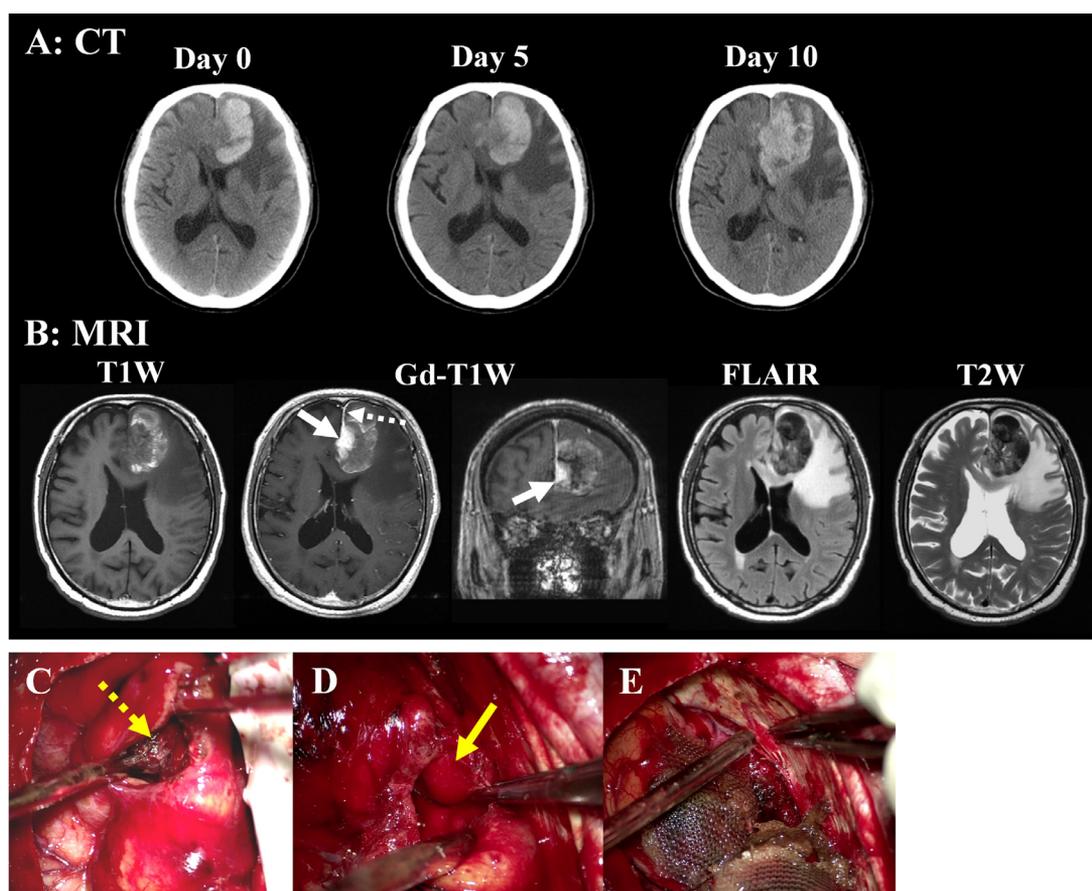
(A) Computed tomography images on admission (Day 0) demonstrating a high-density mass suggesting hemorrhage in the left frontal lobe with large low-density area. On Day 5, the high-density area has spread to the right frontal lobe. The hematoma has enlarged further by Day 10, severely compressing the lateral ventricle. All CT images were performed without contrast media. (B) Magnetic resonance imaging on Day 5 displaying high-signal lesions on T1W, suggesting acute hemorrhage. Gd-T1W demonstrates definite enhancement in or adjacent to the falx (white arrows) with a dural tail sign (dotted arrow), suggesting that the enhanced mass is attached to the falx. FLAIR and T2W demonstrate a massive intraparenchymal low-signal mass in the left frontal lobe, implying a large hematoma caused by the tumor at the falx. (C–E) Intraoperatively, no hemorrhage was found outside the brain. The hematoma was identified in the frontal lobe by corticotomy (yellow dotted arrow). An elastic mass that bled easily was identified medial to the left frontal lobe (yellow arrow). The falx was found to be intact and not adherent to the tumor mass.
